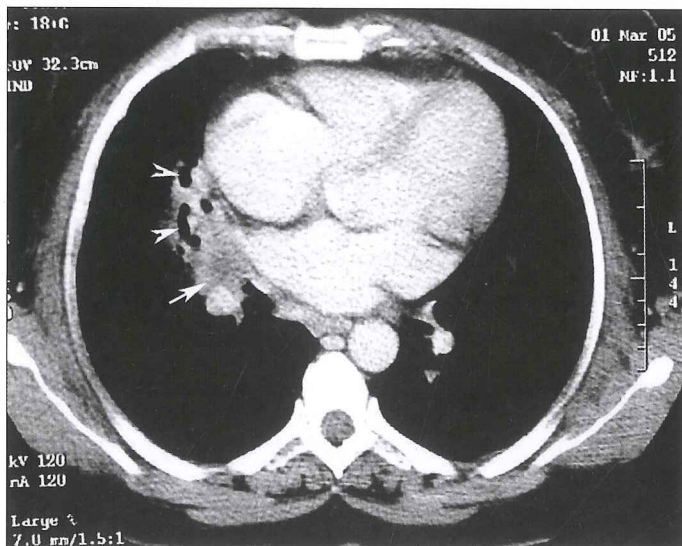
Contrast-enhanced computed tomography image of 22 mm soft tissue mass (arrow) obstructing the right middle lobe bronchus. Note the dilated bronchi (arrowheads) in the atelectatic middle lobe
